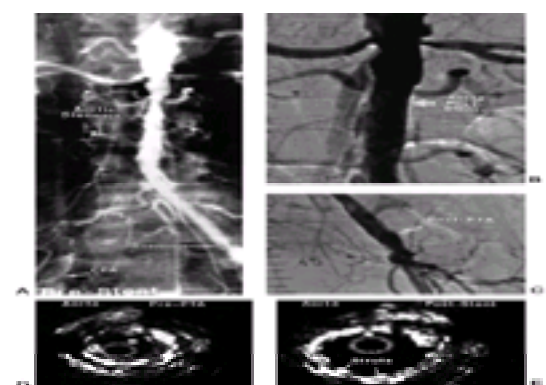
PTA of aorta and common iliac artery in nonischemic (left) side in preparation for cross-femoral graft leads to unexpected resolution of ischemic pain. The patient is a 62-year-old woman, a poor surgical candidate, with rest pain and severe claudication in the right leg. A: Occlusion of right common iliac artery and stenoses in infrarenal aorta and left common iliac artery pre-PTA. Initial strategy was to dilate the stenotic sites, then graft from left to right common femoral artery (CFA). After (B) PTA/stent of aorta and (C) PTA alone of iliac artery, patient’s right (contralateral) leg symptoms disappeared, presumably due to increased left-to-right collateral flow via internal iliac artery tributaries. Planned cross-femoral bypass surgery was therefore canceled. PTA was guided by intravascular ultrasound (IVUS), which demonstrates marked improvement in lumen cross-sectional area of aortic lesion from pre-PTA (D) to poststent (E).
